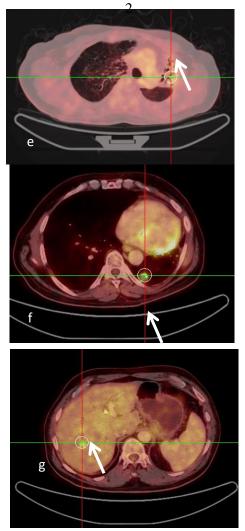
1-axial PET- CT (a-c) the initial study images show: multiple metabolically active FDG avid wide spread lesions (a) at the RT kidney(arrow), (b,c) left lower lung lobe, enlarged bilateral hilar LNs and extensive bilateral pulmonary metabollicaly active FDG avid linear & nodular deposits are seen extending from the enlarged hilar LNs (lymphangitis carcinomatosa) (arrows) 2- (d-f) 3 months follow up study showing rather stationary course
